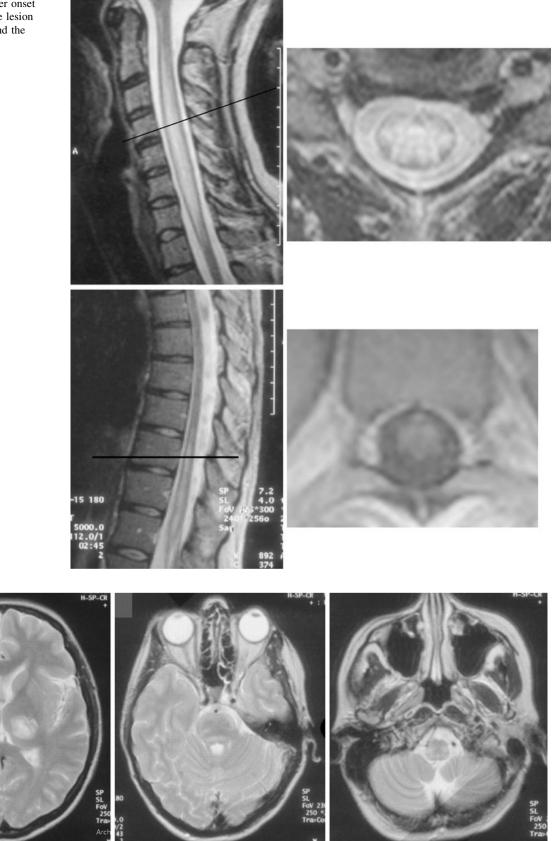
MRI 2 days after onset of symptoms: lesion in the thalamus, pons and medulla oblongata
